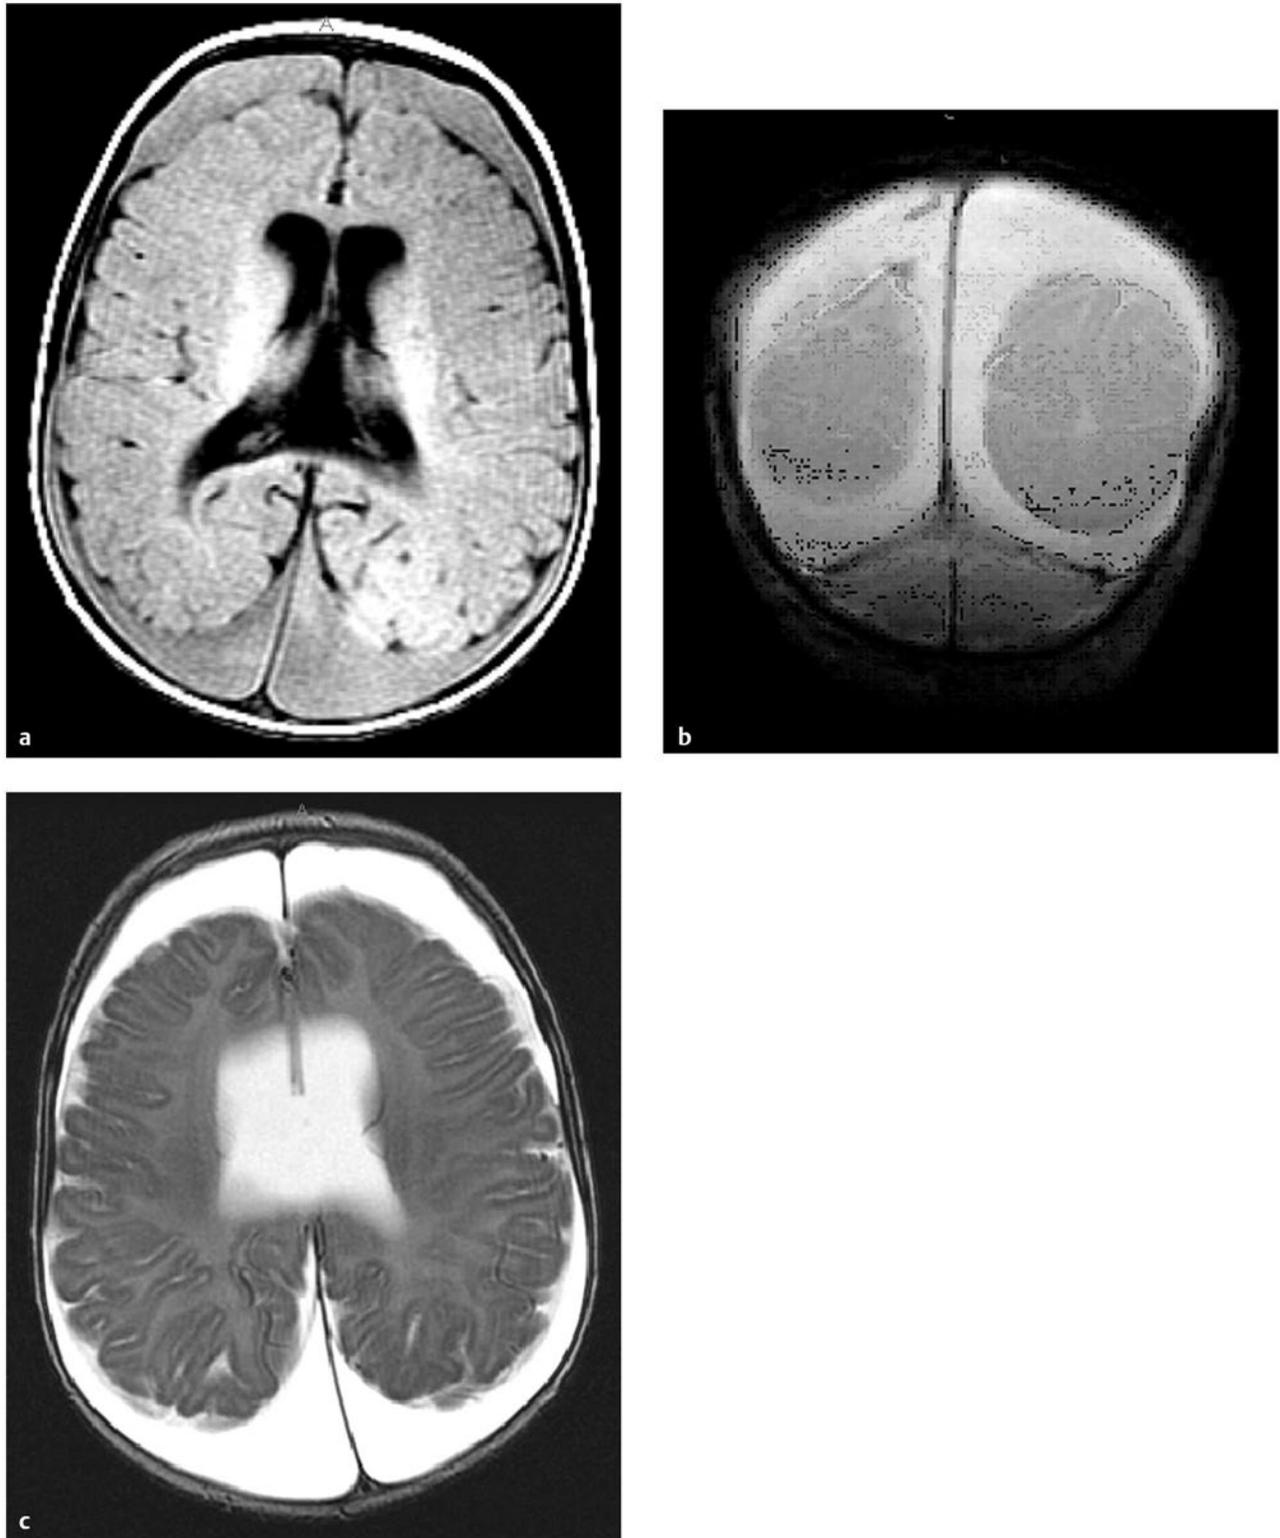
Axial T1-weighted (a), coronal gradient-echo (b), and T2-weighted (c) magnetic resonance images of the brain of a 3-month-old infant with an enlarging head circumference. Note the ruptured parasagittal bridging vein in (b) and the tear in the septum pellucidum, best seen in (c). The infant was also found to have multiple healing fractures. The father, who had been abused as a child, admitted to throwing the infant on the floor and across the room when she cried.
